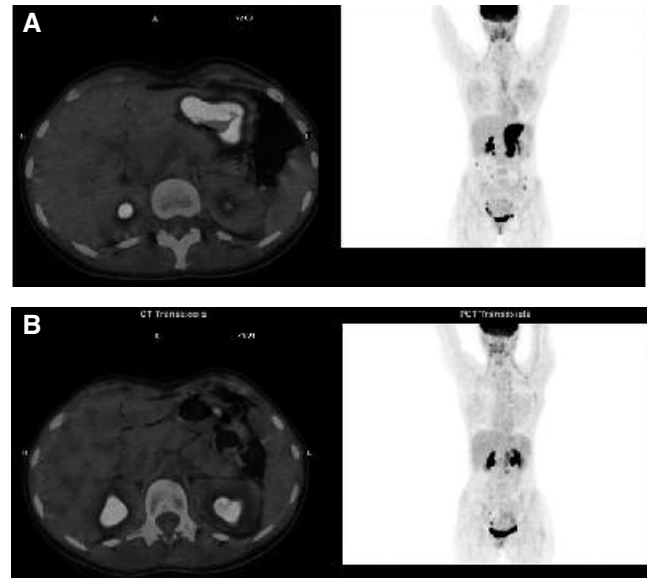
A) 18F-FDG-PET before neoadjuvant therapy revealed abnormal metabolic activity of the whole stomach (SUV_{max} = 21). B) 18F-FDG-PET after neoadjuvant therapy showed a markedly decreased uptake at the level of the stomach (SUV_{max} = 3.8).
